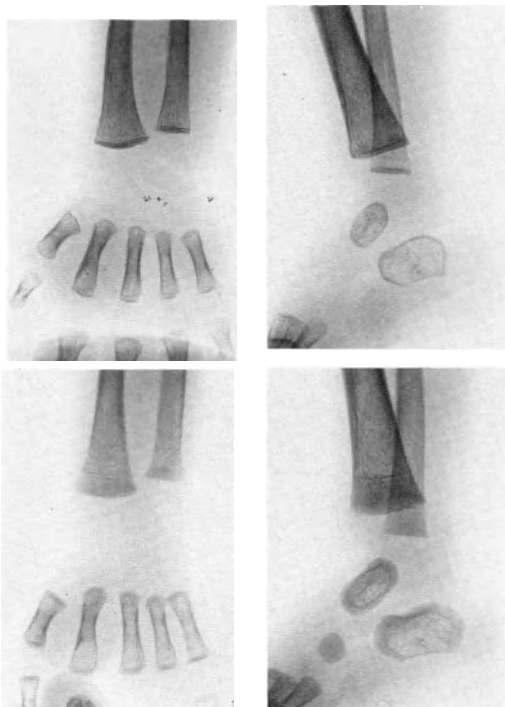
X-rays of hands and feet in a case of congenital hypothyroidism. Top: At age 9 months, just prior to treatment. Bottom: At age 11 months, after two months of treatment. The phase of slow growth preceding treatment can still be recognized after treatment from the dense transversal line in the long bones and from the dense circular line in the talus and calcaneus (KspZ)
